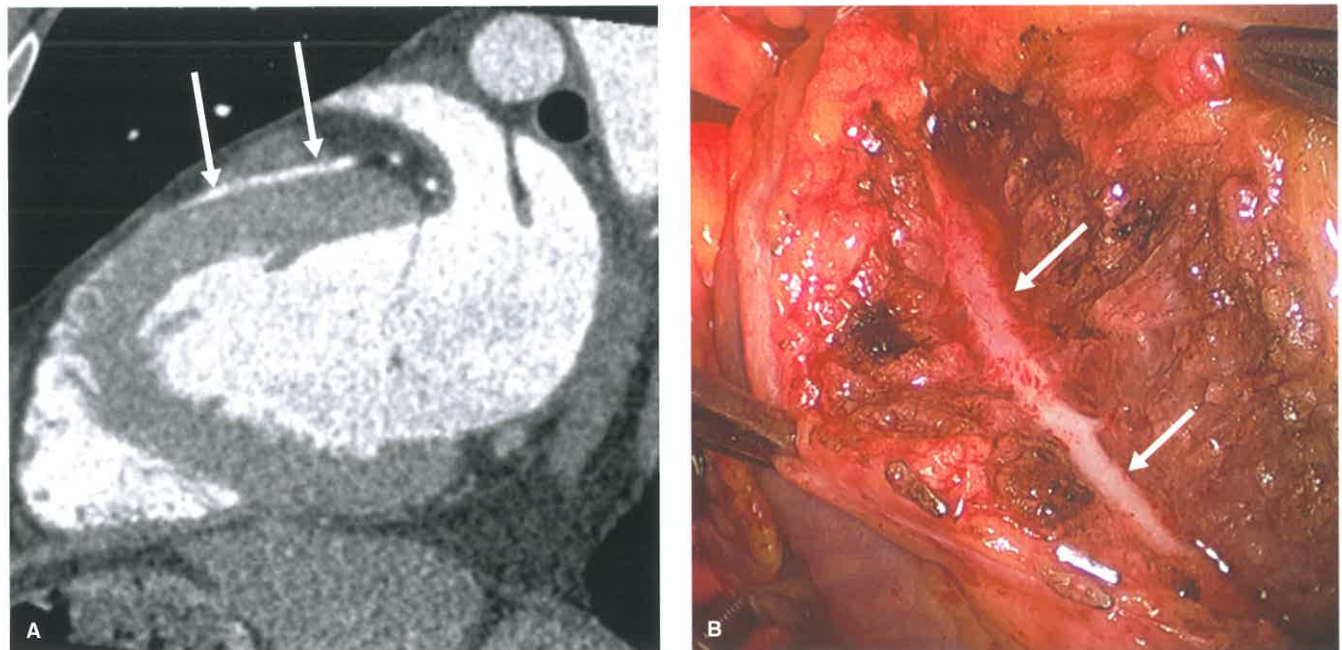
Myocardial Bridging in a 22-Year-Old Man With Repeated Visits to the Emergency Department for Chest Pain. A: Sagittal oblique image from a coronary CTA shows the mid-LAD diving into the left ventricular myocardium (*white arrows*), consistent with a 38-mm myocardial bridge which measured 8 mm in depth. No other abnormalities were found, and stress imaging showed no abnormality. Although this is a common incidental finding and of little clinical significance in the majority of patients, due to his repeated symptoms and lack of other explanation for pain, the patient elected to undergo surgery. B: Surgical image during myotomy shows the mid-LAD surrounded by myocardium (*white arrow*). Two months after surgery, the patient returned to the emergency department with chest pain similar to that experienced prior to surgery.
